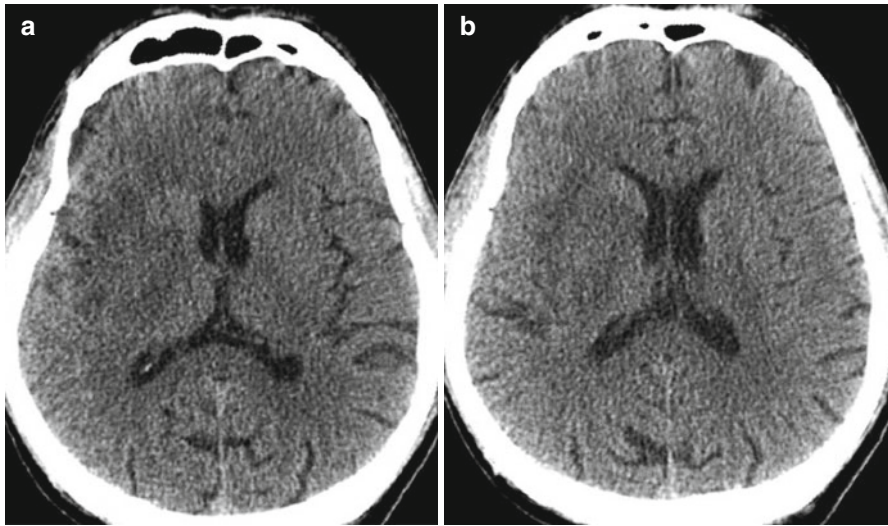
(a, b) Unenhanced CT images show hypodensity and obscuration of the right lentiform nucleus, which appears abnormal in comparison with the left lentiform nucleus. Additionally, these scans demonstrate the loss of grey-white matter differentiation in medial margins of the right insula (insular ribbon sign)
